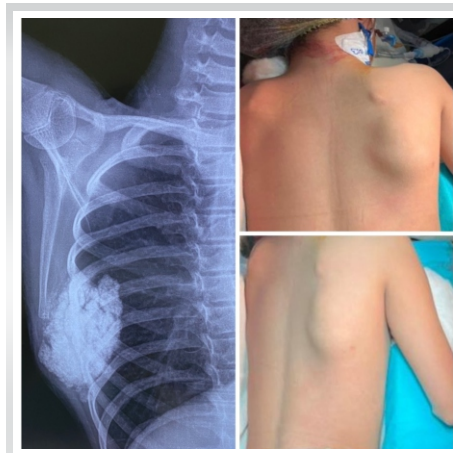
Pre-operative X-ray and clinical photograph.
